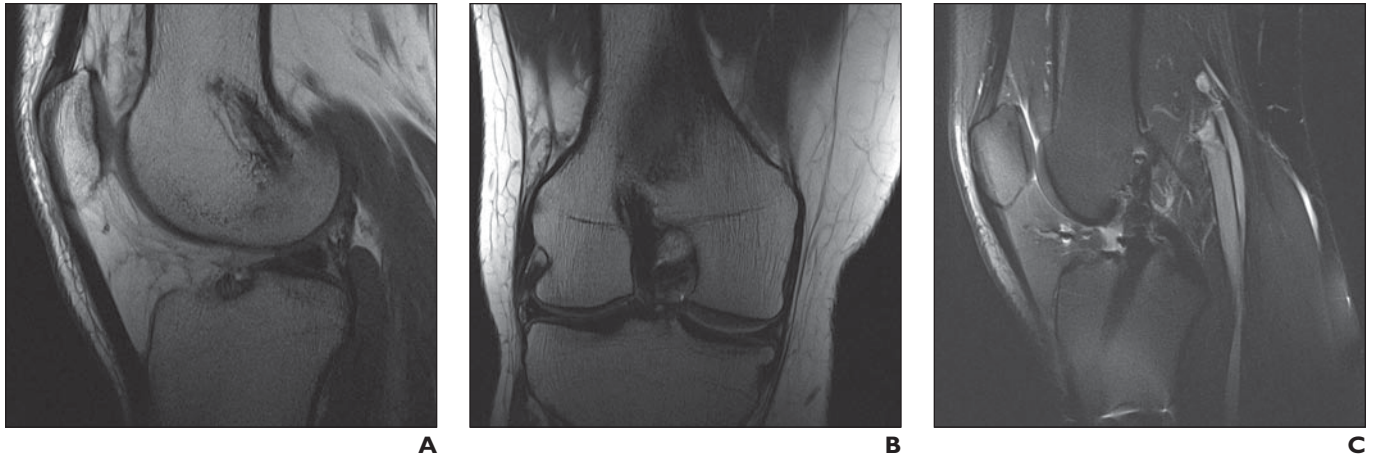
Normal position of tunnel in 18-year-old man who presented for follow-up MRI after anterior cruciate ligament reconstruction. A and B, Sagittal (A) and coronal (B) proton density-weighted MR images show normally positioned femoral tunnel. Position is between 10- and 11-o'clock in this right knee. C, Sagittal T2-weighted fat-suppressed MR image shows normally positioned tibial tunnel opening. Entire tunnel opening is positioned posterior to intersection of MRI equivalent of Blumensaat line (not shown) and tibia.
